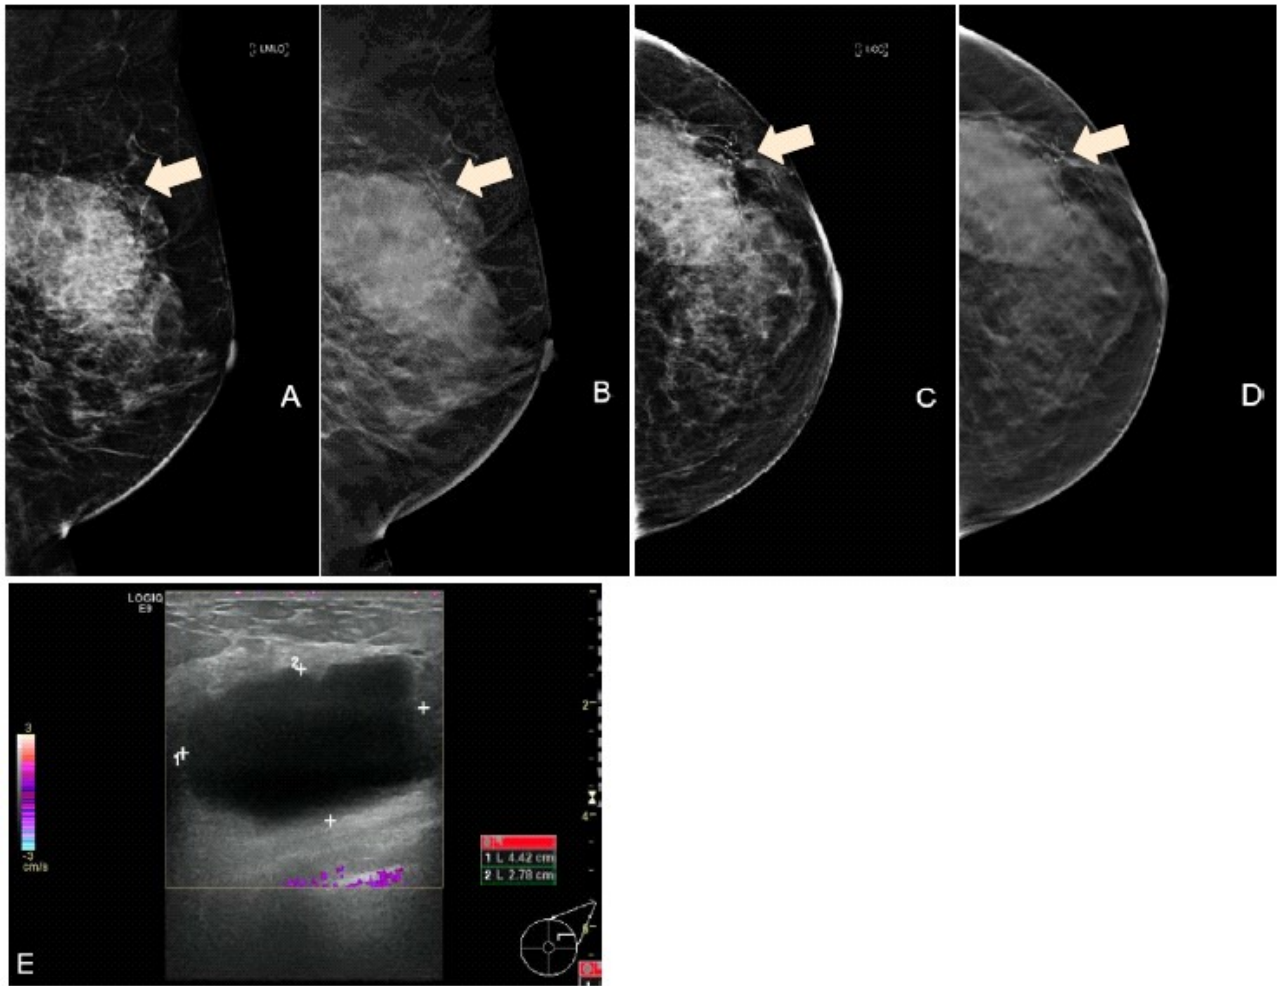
A 56-year-old female patient who had undergone BCT at left upper outer quadrant for surveillance at 6 months, (A and C) DM left MLO and left CC views show suspicious asymmetrical density and architectural distortion at left upper outer quadrant (arrows). (B and D) DBT left MLO and left CC views show well-circumscribed isodense mass at left upper outer quadrant (arrows). (E) Ultrasonography of left breast shows a 2.8 x 4.4 cm cystic lesion without internal vascularity at left upper outer quadrant, probably seroma or hematoma.
